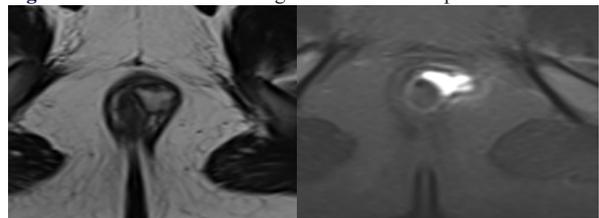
MRI T2W And STIR Images Shows Intersphincteric Abscess
